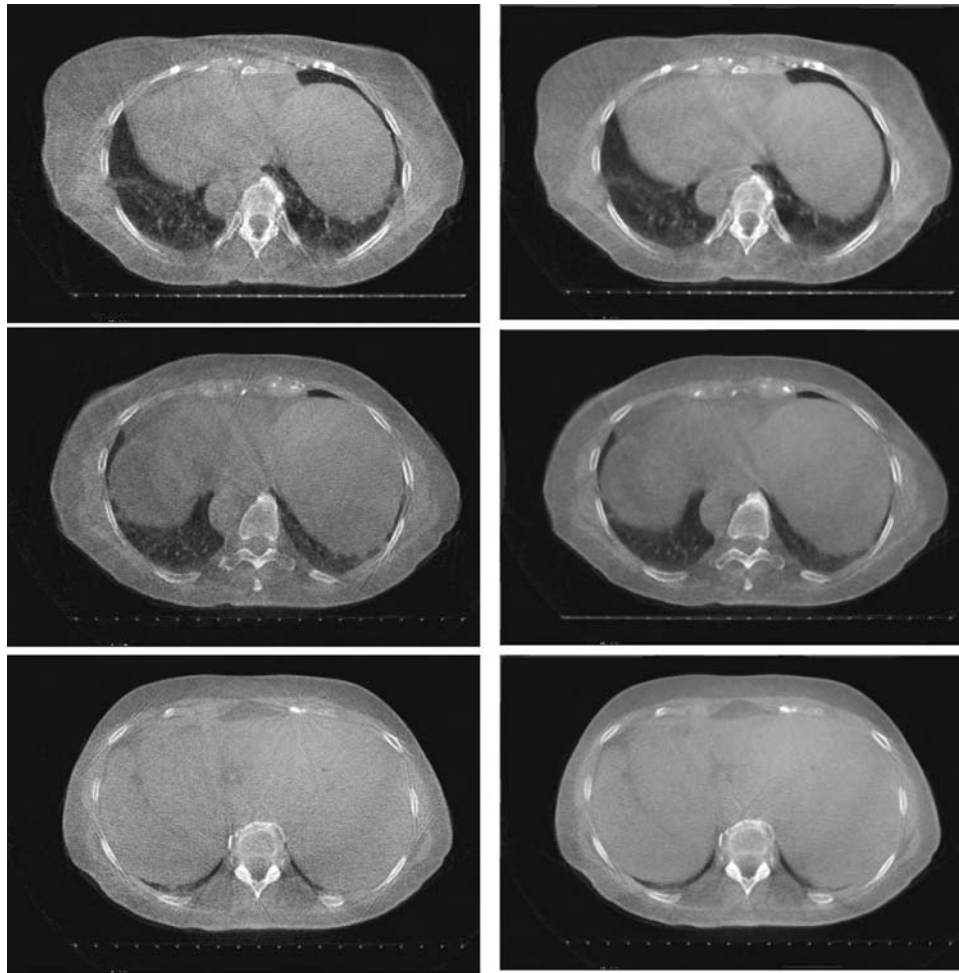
4DCBCT images of a patient. The left column shows three arbitrary slices of the peak inspiration phase, and the right column is the corresponding images after the proposed enhancement with motion model derived by using method B1.
